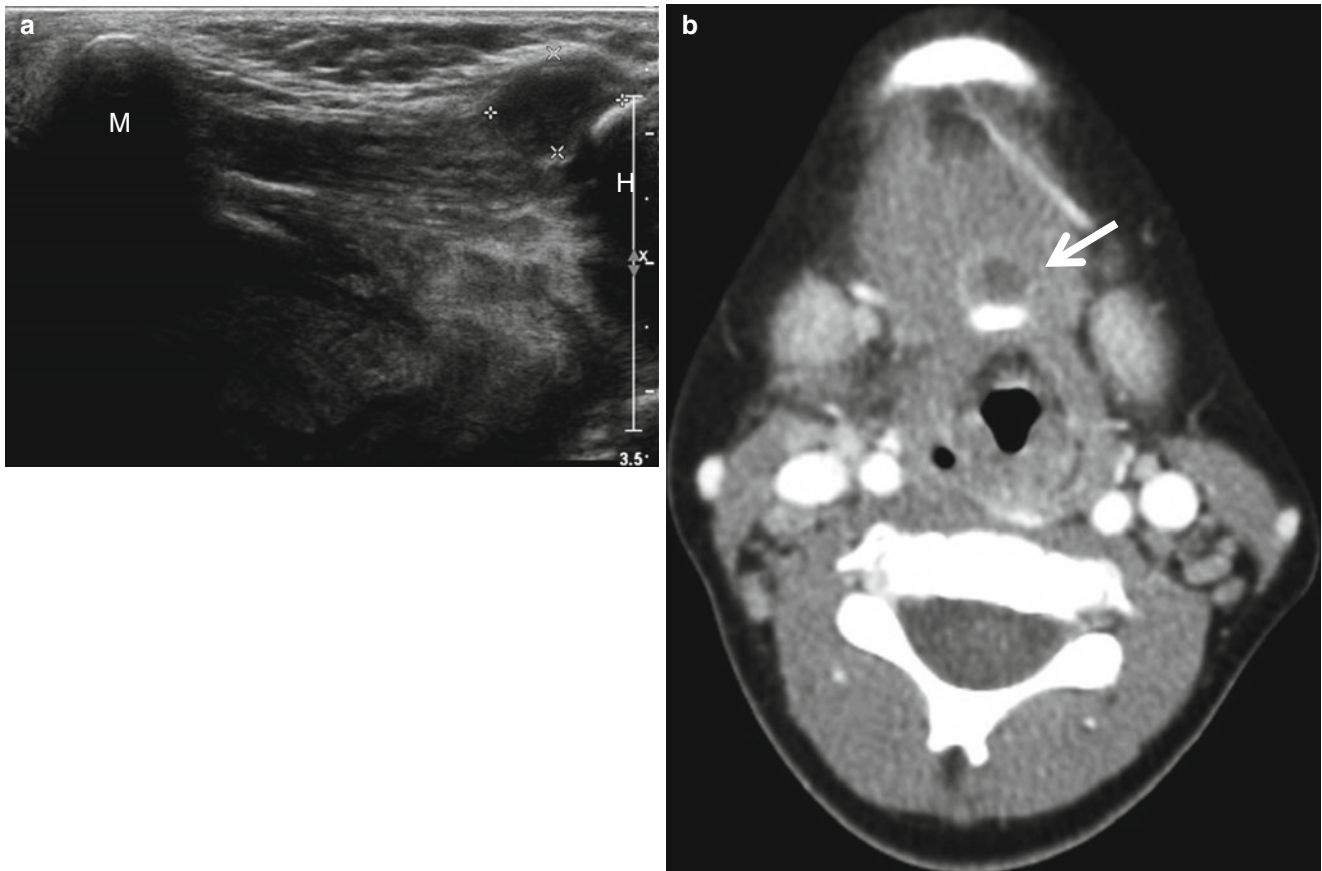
Infected thyroglossal duct cyst. (a) Longitudinal ultrasound of the upper midline neck shows a small anechoic cystic lesion (marked by *cursors*) abutting the hyoid bone (*H*). *M* mandible. (b) Postcontrast
